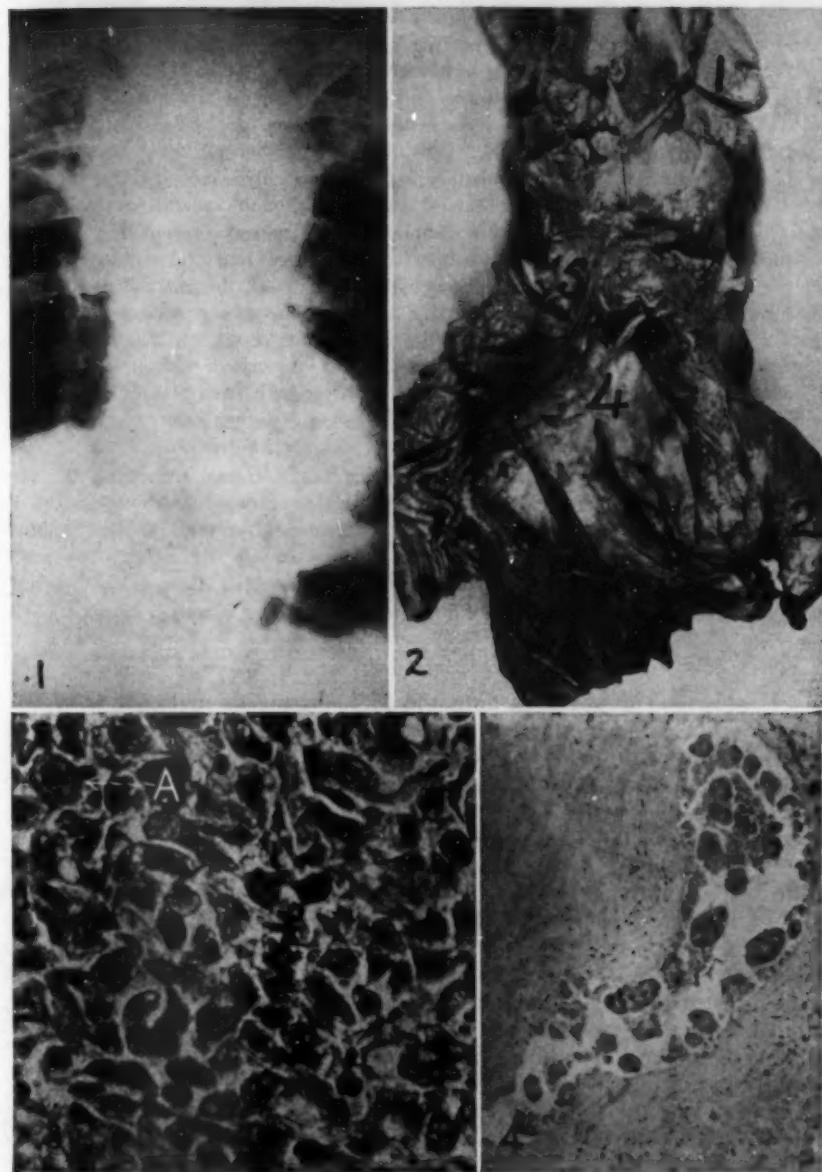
Roentgenogram showing a large mass in the anterior mediastinum. Note also the fibrosis at the right apex.
